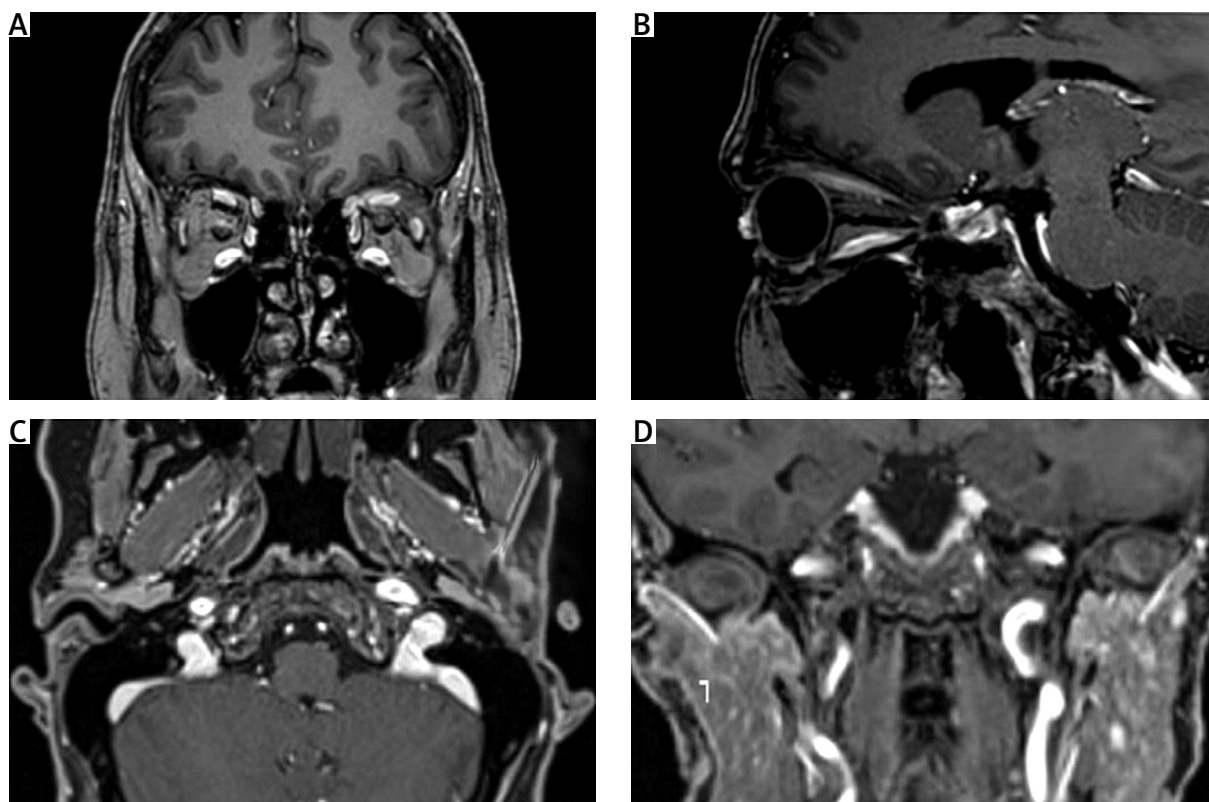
Follow-up magnetic resonance imaging performed 6 months after introduction of treatment showed remission of the orbital (A, B) and skull base lesions (C, D).
